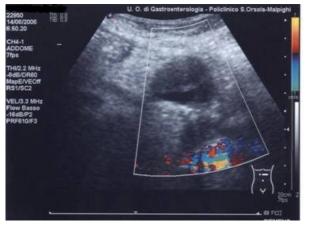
Color-Doppler ultrasonography, transverse section. An hypoechogenic, round, shaped solid mass, 3 cm in diameter with a liquid echo-prive area which appears as an aneurysmatic thrombosed dilatation arising from the splenic artery.
